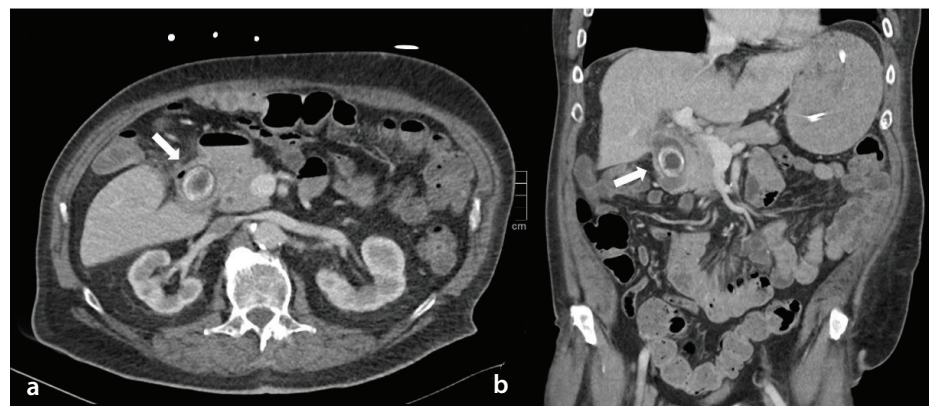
Axial (a) and coronal (b) contrast-enhanced computed tomography images show a markedly distended stomach due to gastric outlet obstruction. A large hyperdense gallstone is identified in the descending duodenum (Bouveret syndrome, white arrow). The gallbladder appears atrophic, with surrounding inflammatory changes suggesting chronic cholecystitis and a possible cholecystoenteric fistula.
